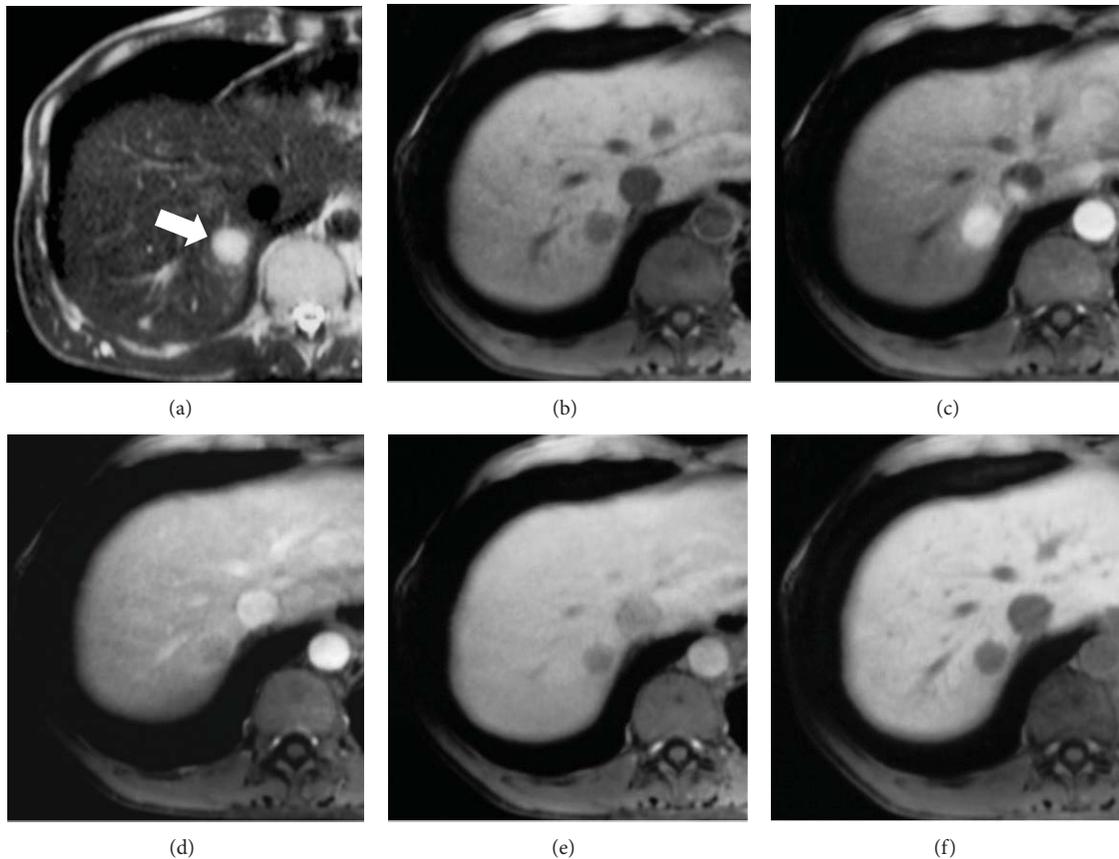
Neuroendocrine hepatic metastasis. (a) On T2w image well-defined homogeneous markedly hyperintense nodule (arrow) in S VII. (b–e) On precontrast T1w fat sat images the lesion is hypointense (b). On contrast enhanced MRI the nodule shows homogeneous evident enhancement in arterial phase (c) with rapid wash out in portal phase, more evident in equilibrium phase. (f) In hepatobiliary phase, 10' after GD-EOB-DTPA, the nodule is hypointense.
